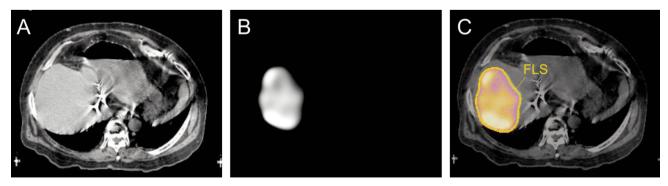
Images for radiotherapy planning. (A) Planning computed tomography (CT), (B) single-photon emission computed tomography (SPECT) and (C) fused planning CT and SPECT image (planning SPECT/CT). The functional liver structure (FLS) is rendered in orange.
